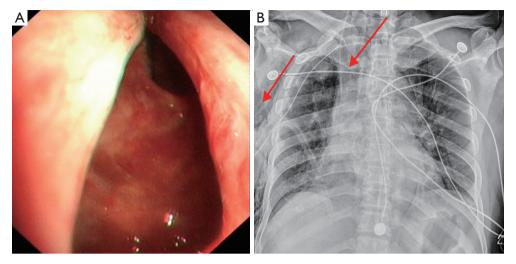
Postoperative day 1: a massive tracheal tear on the membranous part is confirmed by bronchoscopic evaluation (A) following a chest X-ray examination describing a highly suspicious mediastinal emphysema (B). The red arrows indicated subcutaneous emphysema and mediastinal emphysema. The mediastinum becomes wider.
